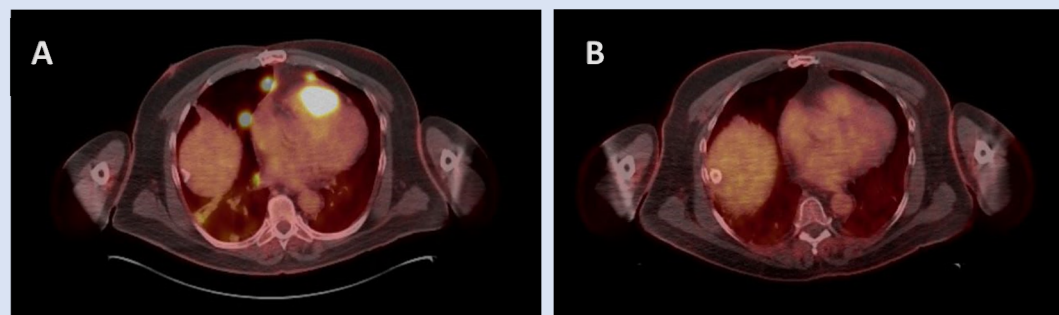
A) On the left, an axial view from the initial PET/CT demonstrates abnormal uptake at an anterior right ventricular myocardial mass and at multiple bilateral pulmonary nodules; B) on the right, an axial view of a PET/CT at the 3-month follow-up demonstrates no significant abnormal uptake in the patient's chest.
